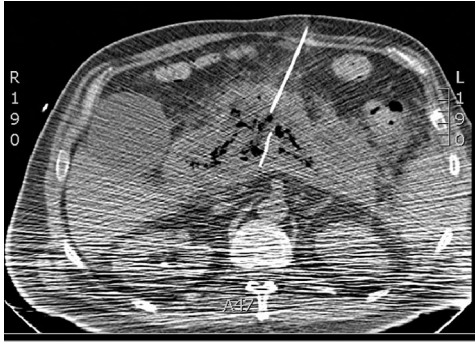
CT-guided drainage of infected pancreatic necrosis.
